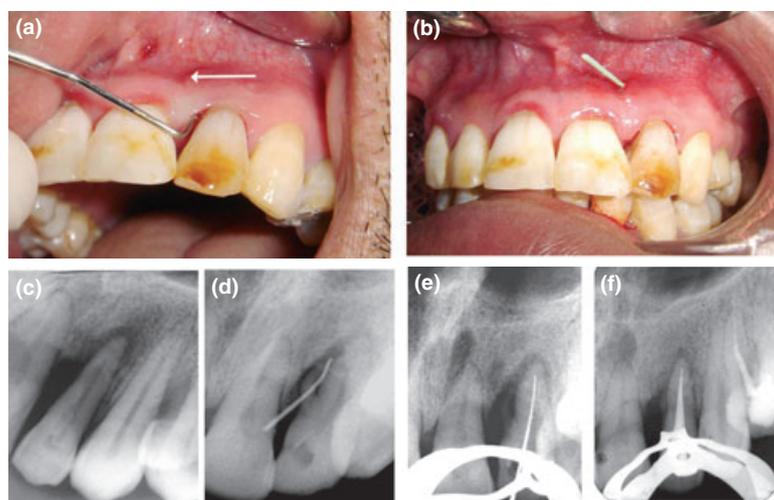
Tooth 22 with a complex radicular lingual groove and its management. (a) Preoperative clinical photograph showing intra-oral sinus and 10-mm-deep periodontal pocket. (b) Preoperative clinical photograph showing gutta-percha inserted into the sinus tract. (c) Preoperative radiograph revealing a lateral periodontal defect around the mesial aspect and a diffuse radiolucency at the apex of tooth 22. (d) The sinus tract was traced with gutta-percha cone to tooth 22 that showed an accessory root surrounded by a large radiolucent area. (e) Working length determination. (f) Post-obturation radiograph.
